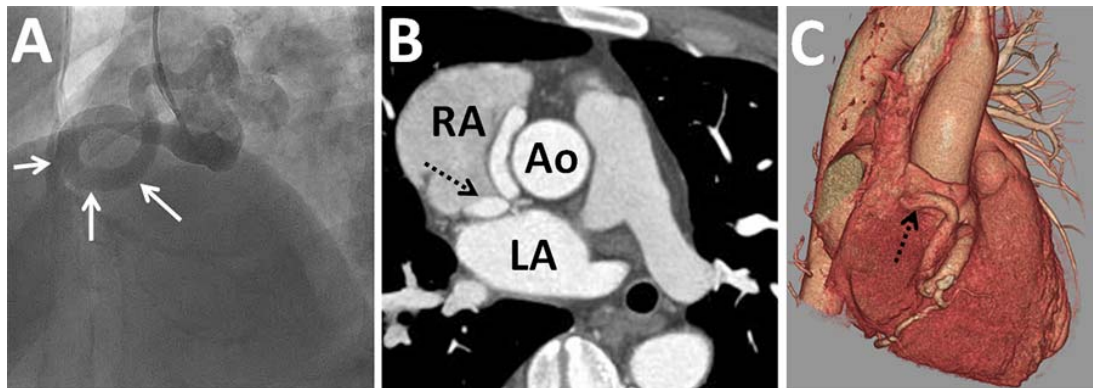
Images obtained in the patient with coronary artery fistula from RCA to the right atrium. Aortic root angiogram (A) shows the abnormal tortuous vessel from RCA (A, arrows), but the exact location of the termination is not identified. Dual-source computed tomography coronary angiography- with oblique axial (B) and three-dimensional volume-rendered (C) images showed communication of fistula from mid-RCA with right atrium (B and C, dashed arrows) (RA; right atrium, LA; left atrium, Ao; aorta).
